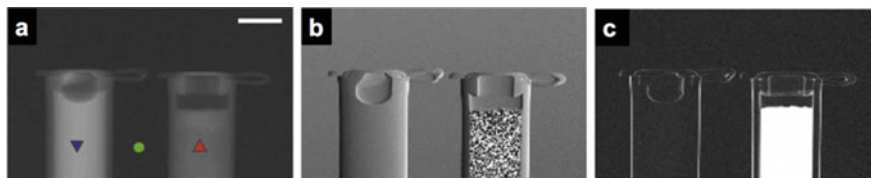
Multi-contrast X-ray images of a test sample containing two plastic containers filled with a liquid (water, left, A) and a powder (sugar, right, B). a Conventional X-ray transmission image. b Differential phase-contrast image. c Dark-field image of the same sample. Adapted from [6]
